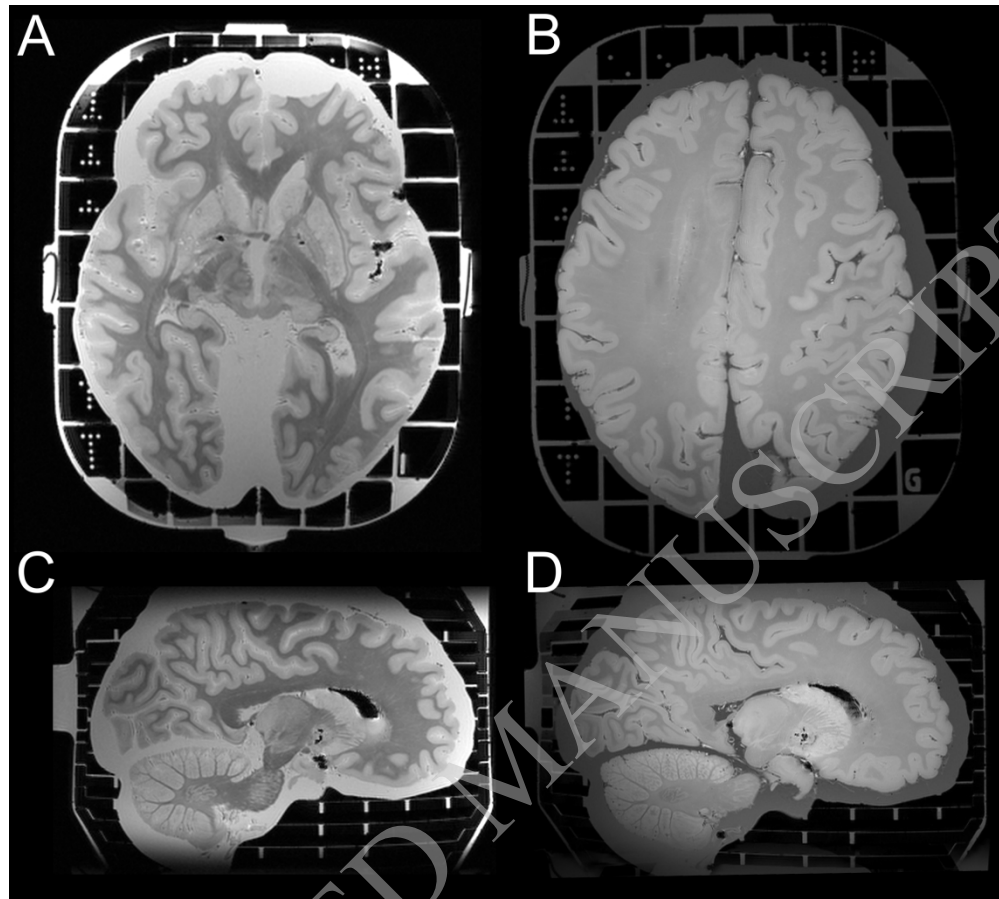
High-resolution brain MRI from a COVID-19 donor using the Brainbox. High-resolution magnetic resonance imaging (MRI) of a brain from a COVID-19 donor, employing gradient echo magnetization transfer imaging (A and C) and gradient echo quantitative susceptibility mapping (B and D). Nominal resolution: 0.4 mm isotropic.
